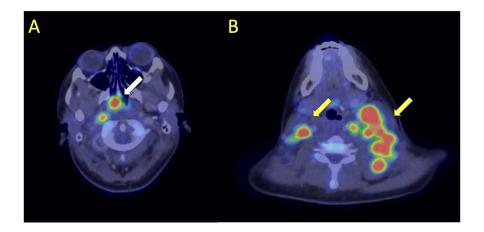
PET/CT imaging before induction chemotherapy demonstrating: A) Avid nasopharyngeal mass, more prominent on the right than the left side (white arrow). B) Involvement of bilateral lymph nodes (yellow arrows).
